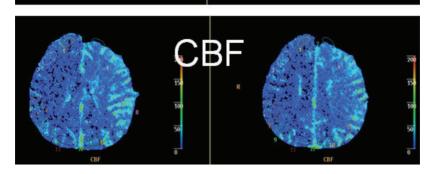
CT perfusion shows increased cerebral blood volume (CBV) as well as cerebral blood flow (CBF) in the left MCA territory.
